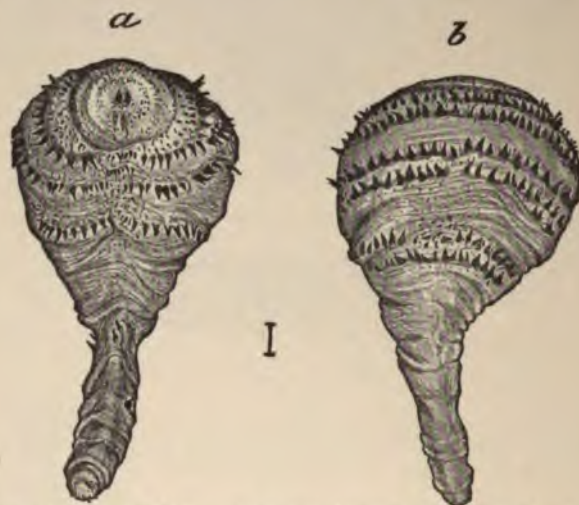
DERMATOBIA NOXIALIS*. *a*, VENTRAL ASPECT; *b*, DORSAL ASPECT. GREATLY ENLARGED.—(From "Insect Life"; Osborn, Bull. No. 5, Div. Entomology, U. S. Dept. Agriculture.)
